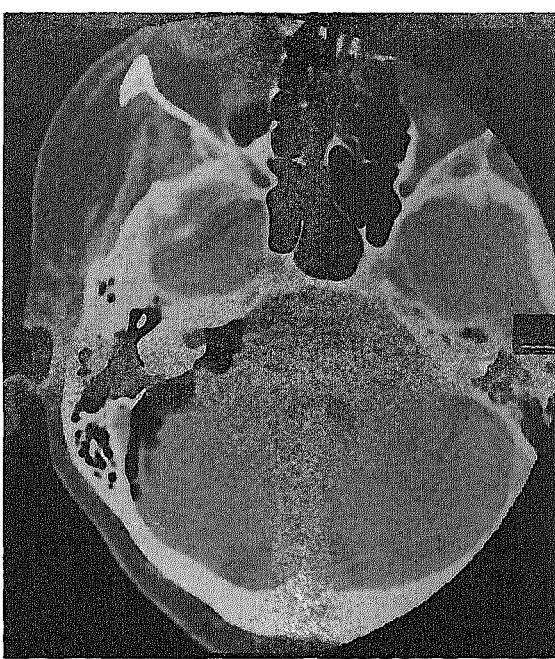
(top left). Left acoustic neuroma, CT pneumocisternogram. A small tumor mass fills the internal auditory canal. The cerebellopontine cistern and cisternal portion of the eighth cranial nerve are normal.
